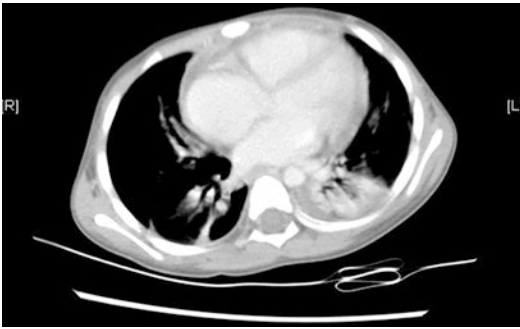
Consolidation of left lower lobe and pleural effusion was noted on chest computed tomography scan on day 20 of fever
